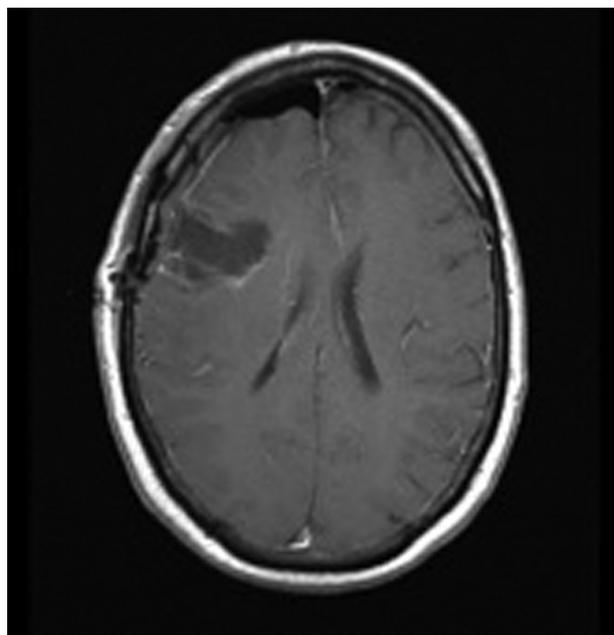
T1 axial postoperative magnetic resonance imaging with no residual contrast enhancement.
